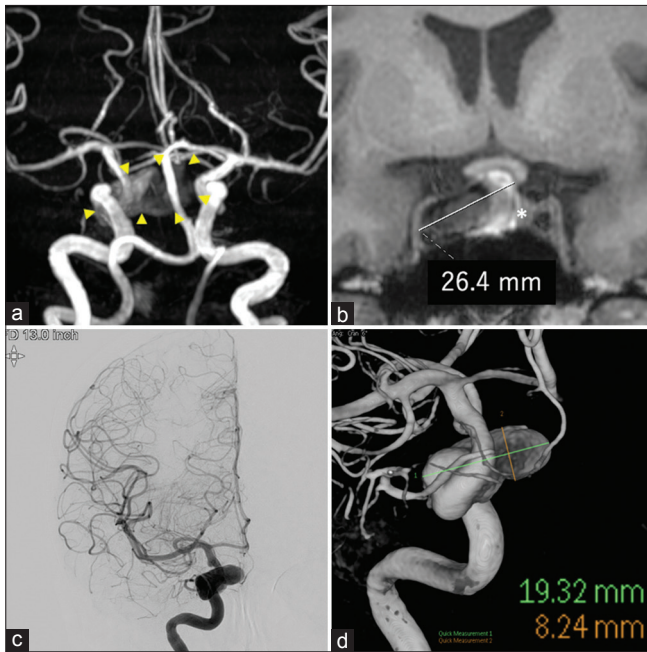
(a) Magnetic resonance angiography showing a giant right cavernous internal carotid artery (ICA) aneurysm. The aneurysm is surrounded by arrowheads. (b) T1-weighted coronal magnetic resonance imaging showing a thrombotic aneurysm measuring 26.4 mm at the largest diameter, as indicated by white line. The asterisk refers to the pituitary gland that is ablated by an aneurysm. (c) Digital subtraction angiography shows the right cavernous ICA aneurysm. (d) 3D rotational angiography shows aneurysm excluded thrombosis measuring at 19.3 mm at largest diameter, as indicated by green line. The height of the aneurysm is 8.2 mm, indicated by the orange line.
